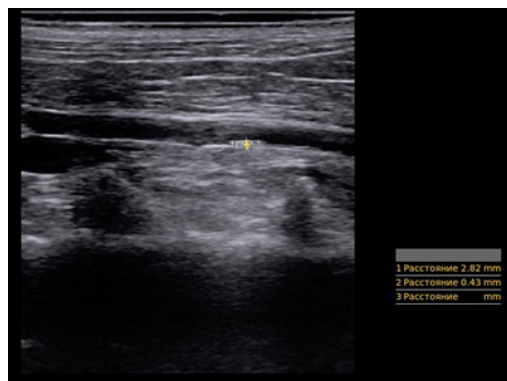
(A) Abdominal aorta of a male rabbit. (B) Abdominal aorta at the level bifurcations. (C) Doppler mode of abdominal ultrasound. (D) Doppler mode of ultrasound aorta of a male rabbit. Measurement of LSSC. studies of the carotid arteries of a male rabbit. Measurement of LSSC.
